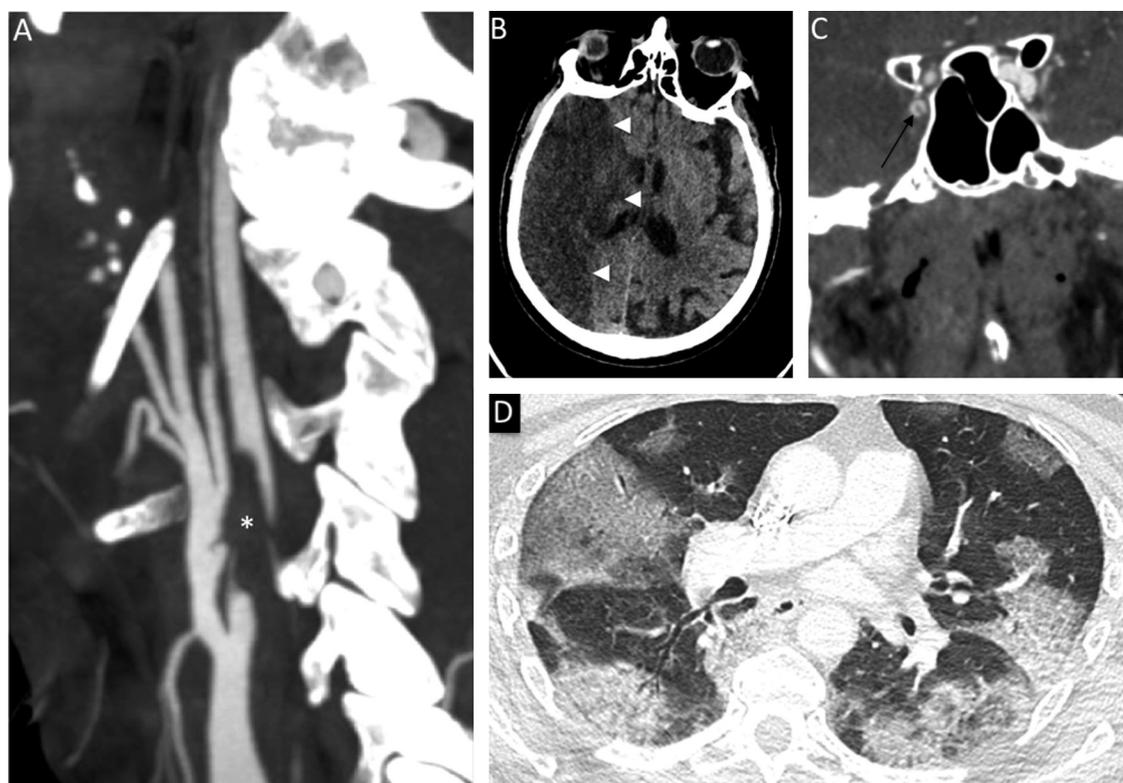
CTA showed a huge, nonocclusive ILT adherent to the right proximal ICA wall. Note the absence of atherosclerotic plaque adjacent to the thrombus (A, asterisk). CT scan performed at 24 hours disclosed a clear hypodensity within the right hemisphere consistent extensive right MCA territory infarct (B, arrowhead) and a novel nonocclusive ILT within the cavernous segment of the right ICA (C, arrow). Chest CT demonstrated peripheral ground-glass pulmonary findings consistent with severe COVID-19 infection (D).
